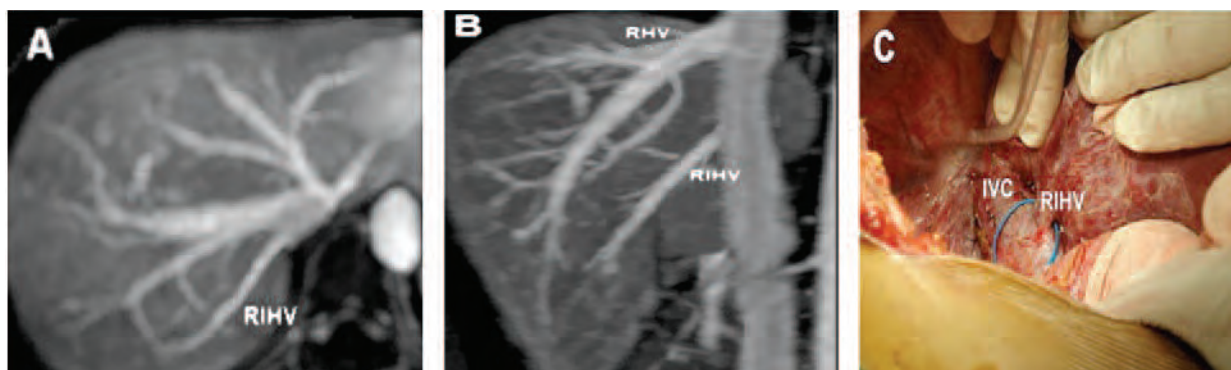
A 25-year-old female potential living-liver donor. Venous phases axial (A) and oblique coronal (B) 3-dimensional maximum intensity projection images of the hepatic veins show a large (> 3 mm) right inferior hepatic vein draining the posterior segment of the right lobe separately into the inferior vena cava. It was located more than 5 mm from the main right hepatic vein. The corresponding intraoperative image (C) clearly shows the right inferior hepatic vein draining into the inferior vena cava as demonstrated in preoperative computed tomography images.
